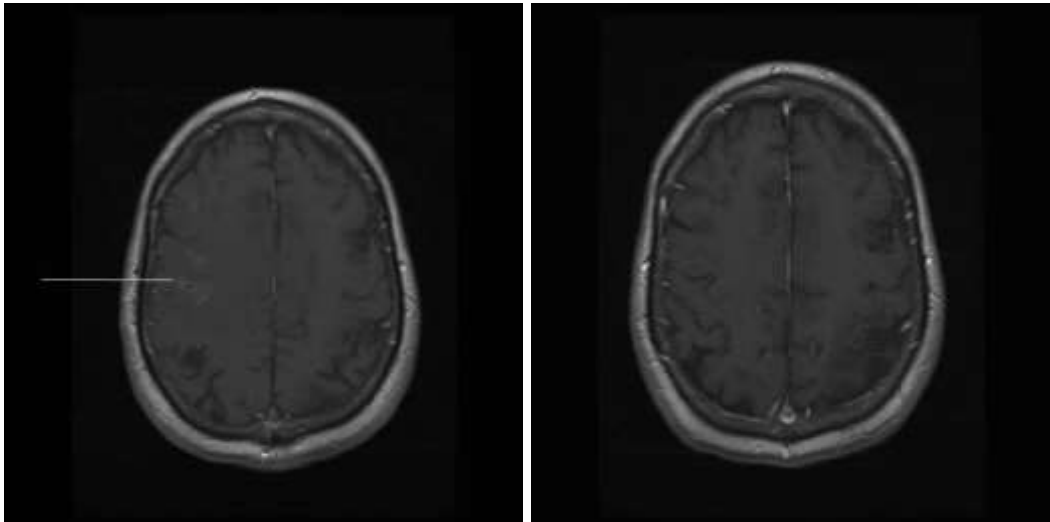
Primary CNS vasculitis. T1-weighted MRI of the brain demonstrates gyral enhancement after intravenous administration of gadolinium before treatment (A), that resolves after immunosuppressant therapy (B). Reproduced with permission from [10].
